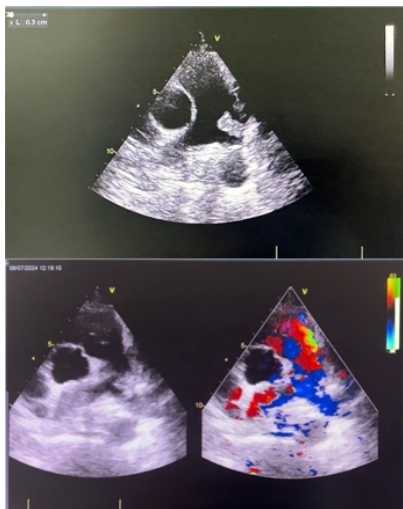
Endocarditis vegetation size 1.3x0.5cm and jet PDA in patient echocardiography
